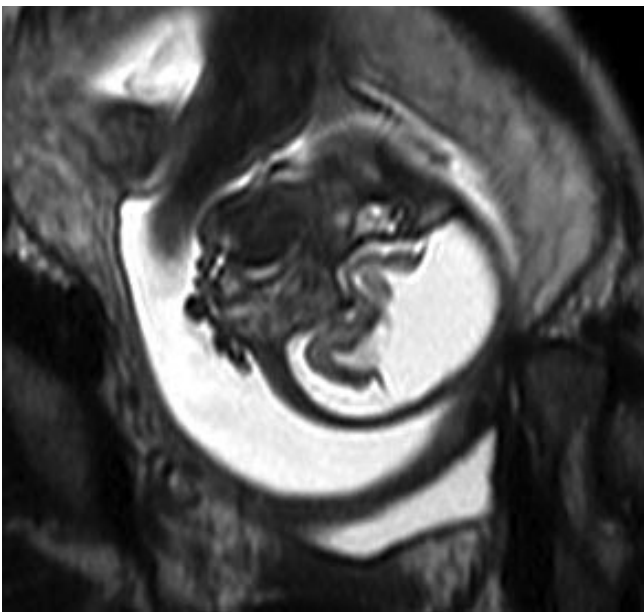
Prenatal sagittal MRI demonstrating hydranencephaly. Note preservation of inferior aspect of frontal lobe and infero-medial aspect of temporal lobes of brain.
